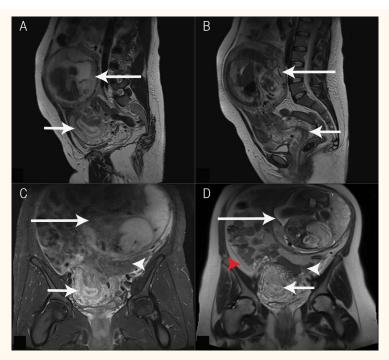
T2-weighted fat-saturated (A & B) sagittal and (C & D) coronal magnetic resonance imaging (MRI) of the abdomen and pelvis of a pregnant patient. There was evidence of a pregnancy apparently remote from the cervix, with a very thin hypointense wall in the left hypochondrium (long arrows). On the sagittal MRI images, an (A) empty normal-looking uterine body (short arrow) could be observed, which was (B) connected to the cervix (short arrow). The (C & D) bowel loops seemed to be interpositioned between the gestational sac and the cervix (white arrowheads). There was (D) free fluid in the abdomen (red arrowhead).
